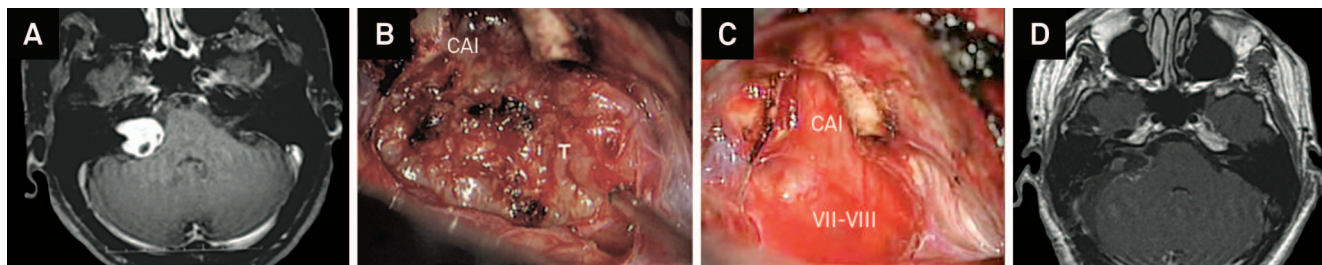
(A) VS in the right CPA; (B) Exposure of the posterior portion of the tumor (T) after opening of the internal auditory canal (CAI); (C) The arachnoid envelop that protects the cranial nerves during dissection seen after total tumor removal; and (D) Postoperative MRI demonstrating no residual tumor.
